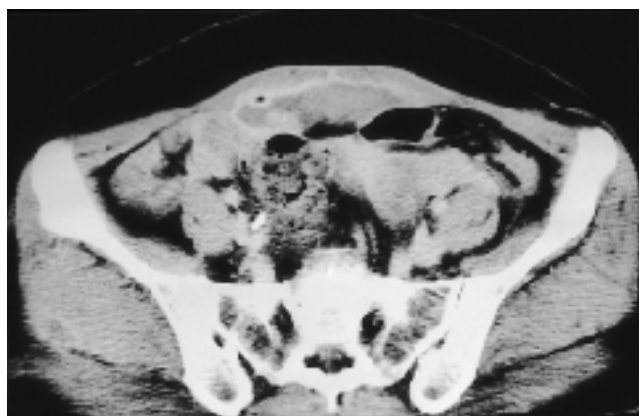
Follow-up CT scans after 1 month showed markedly decreased size of the hematoma in abdomen.
